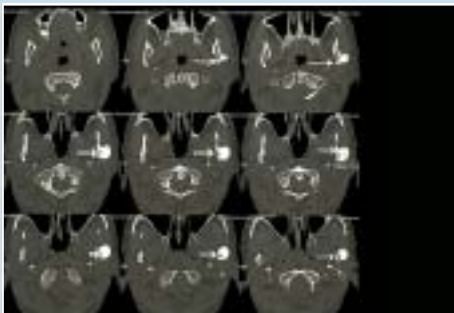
Axial CT scan showing hyperdense radiopaque mass attached to outer cortex of mandible in condyle region.
